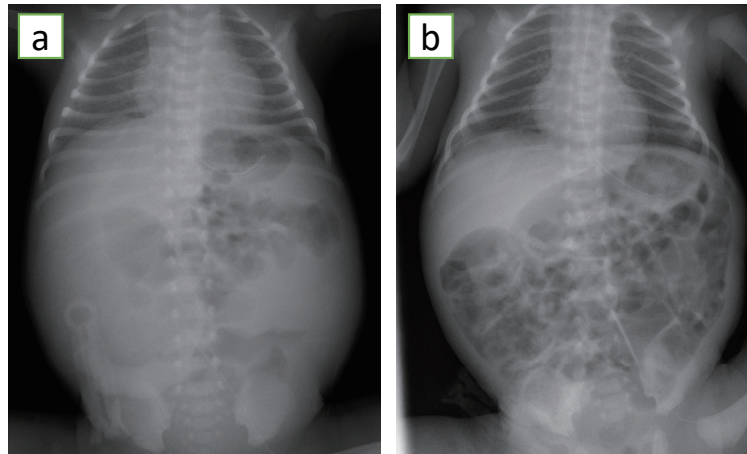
Plain X-ray images: (a) On day 0, relative paucity of intestinal gas in a distended abdomen was noted; and (b) on day 1, multiple dilated bowel loops with air visible in the rectum were noted.
